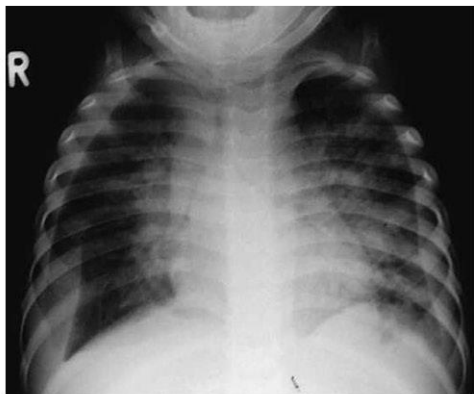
Bilateral pleural effusions visible on chest radiograph. Aspirated fluid was milky and fulfilled the criteria for a chylothorax. Nodal compression of both main bronchi is present.
